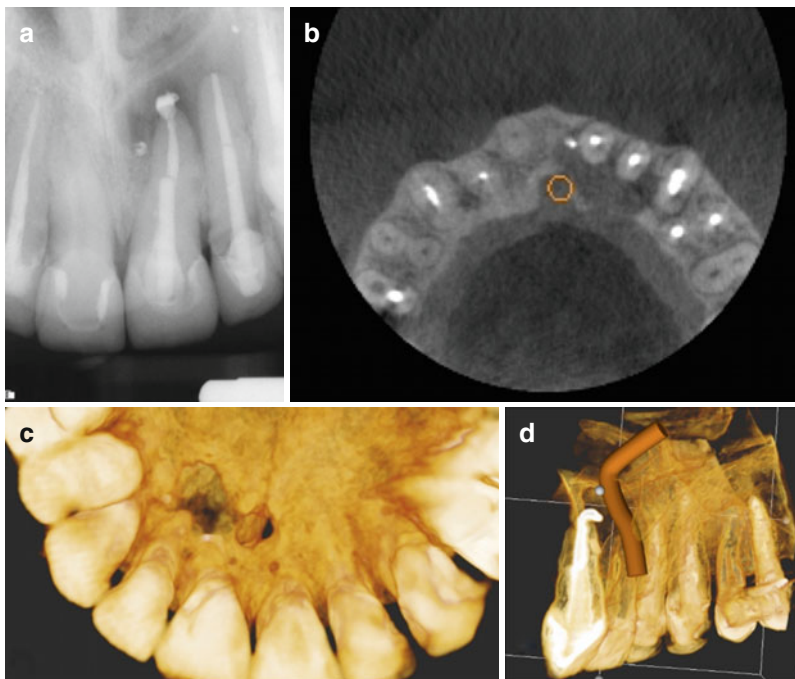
Periapical radiograph of the maxillary anterior region showing a periapical lesion associated with tooth #9 (a). (b) Axial view showing the extent of the lesion, palatal plate perforation, and relationship of the nasopalatine neurovascular bundle to the periapical lesion (b). Palatal view of the 3D reconstruction showing perforation of the palatal plate (c). 3D reconstruction showing the nasopalatine bundle (d)
